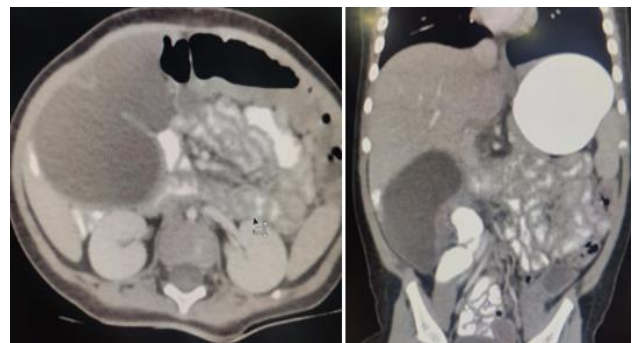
CT showing mesenteric cyst, transverse and coronal view.
